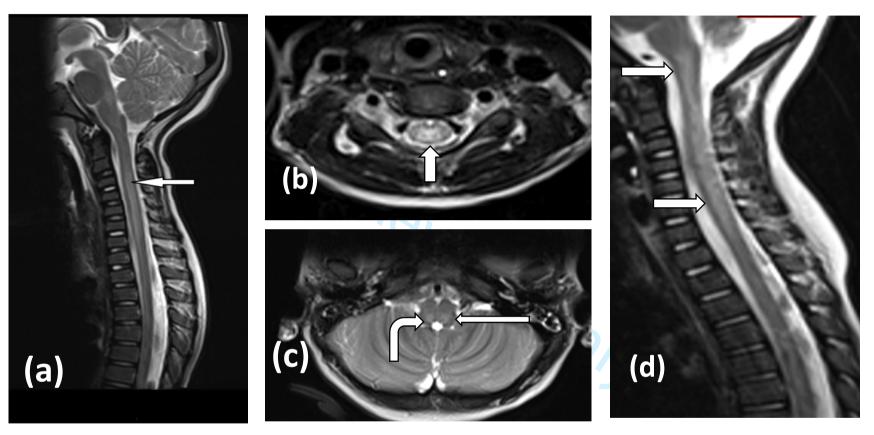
Magnetic resonance imaging (MRI) of the spinal cord and brainstem in acute flaccid myelitis caused by enterovirus D68. The saggital T2-weighted sequences (a,d) showing longitudinal hyperintense signal and the Axial T2-weighted sequences (b,c) showing hyperintensity in spinal cord grey matter (b) and dorsal brainstem (c).
